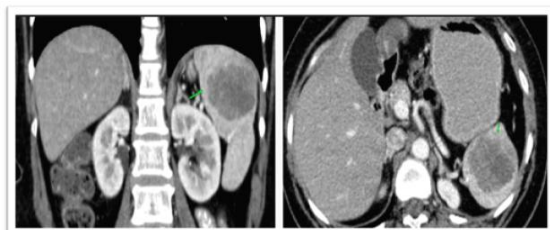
Contrast-enhanced CT of the abdomen (coronal and axial images) demonstrating a rounded, well-defined, hypodense collection with a peripherally enhancing wall at the superior pole of the spleen (arrows), consistent with a splenic abscess. No free intraperitoneal fluid was present.
